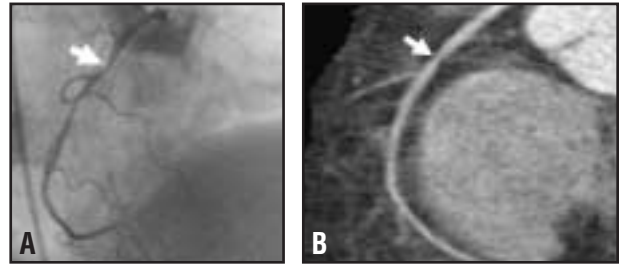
Follow-up exam of a 57-year-old with a questionable new inferior wall ischemia. A: 30% RCA stenosis was previously noted at conventional angiography (arrow). B: Coronary CTA confirmed that the stenosis (arrow) was unchanged two years later.
